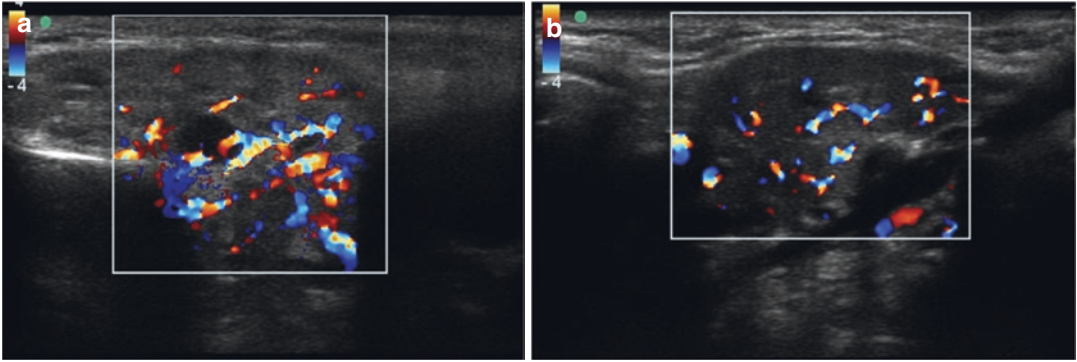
Hypervascularity of active inflammation of the parotid gland (a) and submandibular gland (b) assessed by color Doppler
